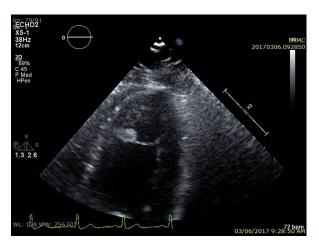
Transthoracic zoomed apical four-chamber view depicting a round mobile mass attached to the lateral wall of the LV via a thin chord-like filament.
